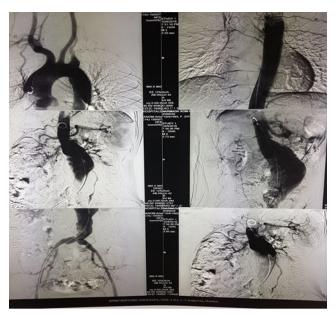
Contrast enhanced CT scan with an aortogram demonstrated a 8×8 cm partially thrombosed pseudoanerysm just after the origin of superior mesenteric artery extending to both the common iliac artery origin.
